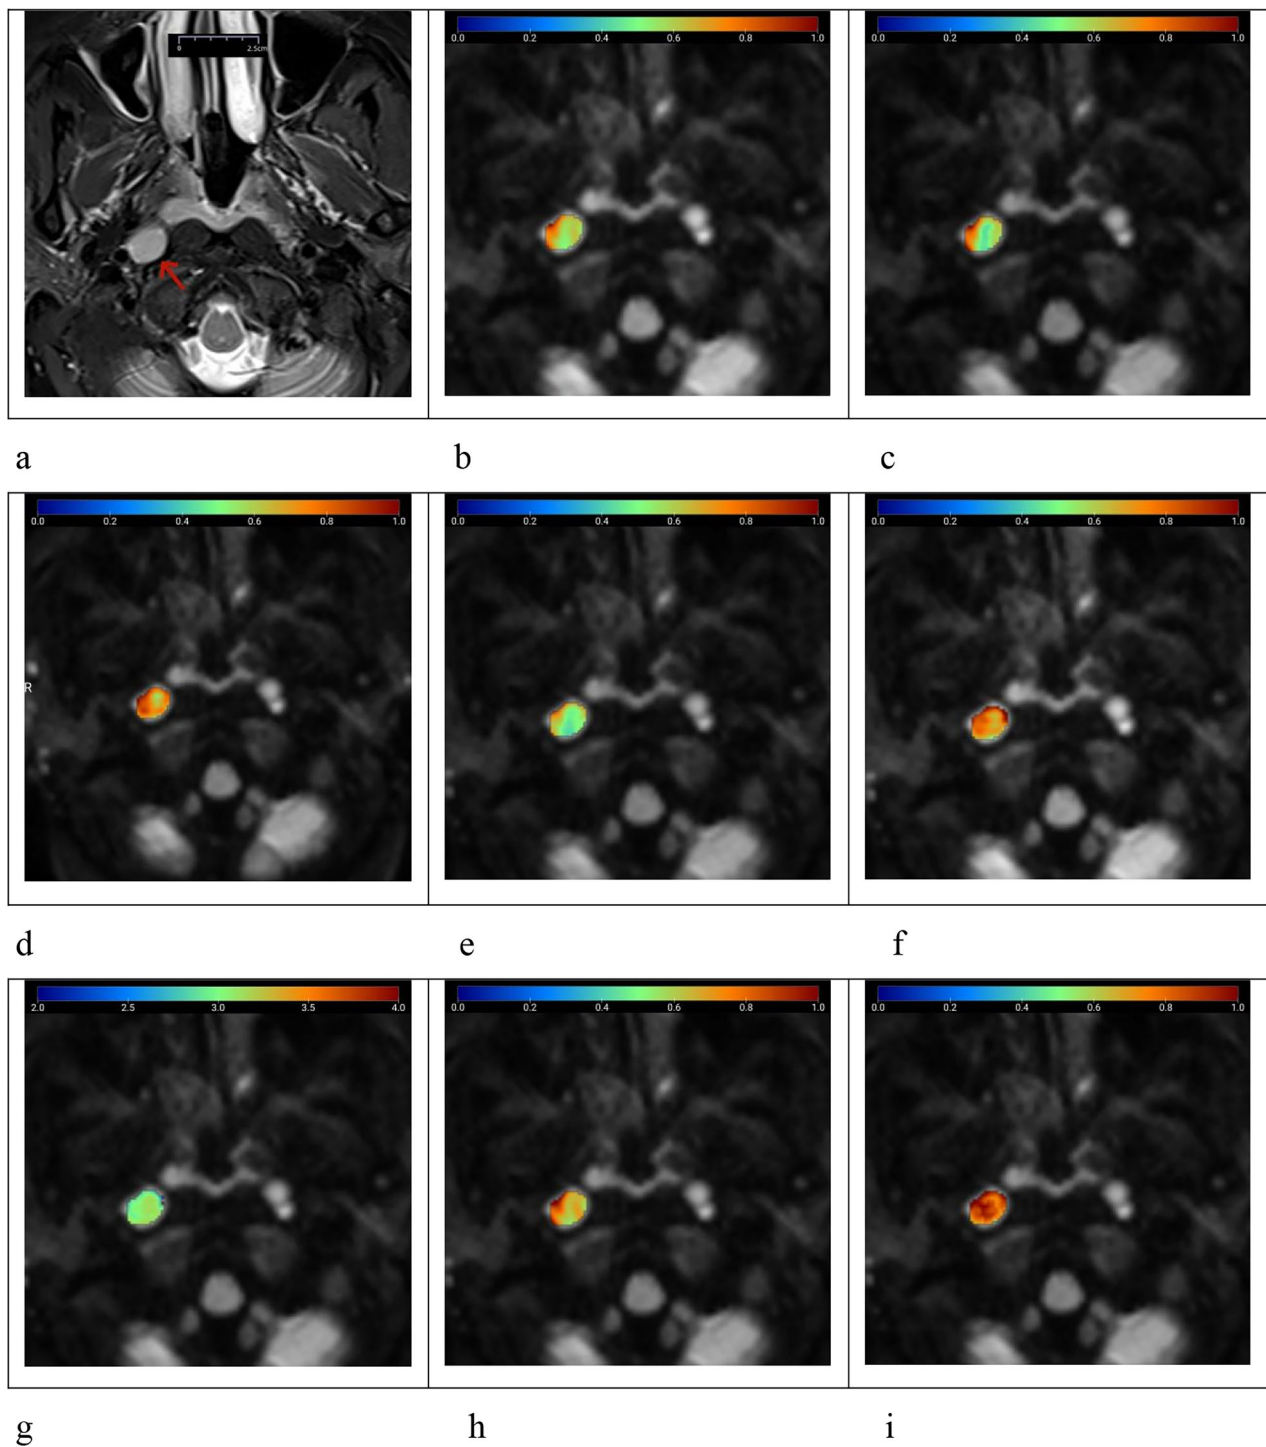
Female patient, aged 51 years, with nasopharyngeal non-keratinizing squamous carcinoma and a metastatic right retropharyngeal lymph node (arrow). a T2-weighted imaging with fat saturation shows the lymph node with a homogeneously slightly high signal, a maximum axial diameter of 1.19 cm, and minimal axial diameter of 0.93 cm. b–i Pseudocolor maps of the quantitative parameters $ADC = 0.630 \mu\text{m}^2/\text{ms}$ (b), $DDC_{SEM} = 0.612 \mu\text{m}^2/\text{ms}$ (c), $\alpha_{SEM} = 0.755$ (d), $D_{FROC} = 0.589 \mu\text{m}^2/\text{ms}$ (e), $\beta_{FROC} = 0.829$ (f), $\mu_{FROC} = 3.107 \mu\text{m}$ (g), $D_{CTRW} = 0.740 \mu\text{m}^2/\text{ms}$ (h), and $\beta_{CTRW} = 0.879$ (i), derived from conventional DWI, SEM, FROC, and CTRW diffusion models. ADC, Apparent diffusion coefficient; CTRW, Continuous-time random walk; DDC, Distributed diffusion coefficient; DWI, Diffusion-weighted imaging; FROC, Fractional-order calculus; SEM, Stretched-exponential model
